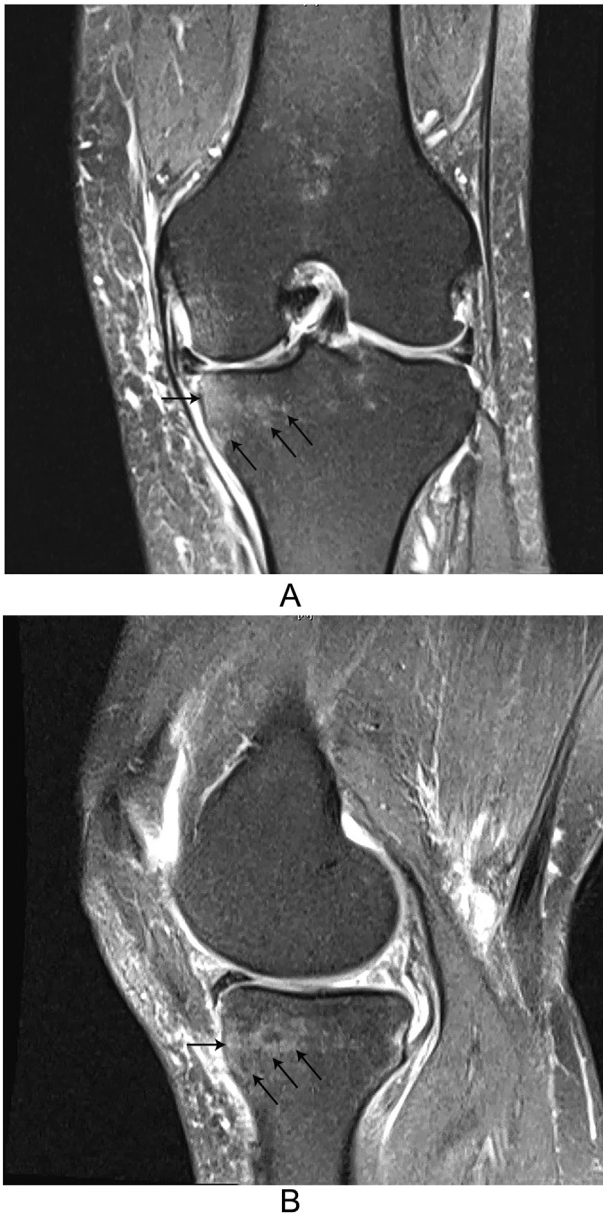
A 54-year old female underwent medial meniscectomy and subchondroplasty of the medial tibial plateau of the left knee. The preoperative MRI obtained 3-weeks before the procedure shows mild hyperintensity consistent with a focal bone marrow edema (*black arrows*) and medial compartment cartilage thinning, indicative of a bone marrow lesion. (a) coronal T2-weighted PD fat saturated MRI of the left knee and (b) sagittal T2-weighted PD fat saturated MRI of the left knee.
